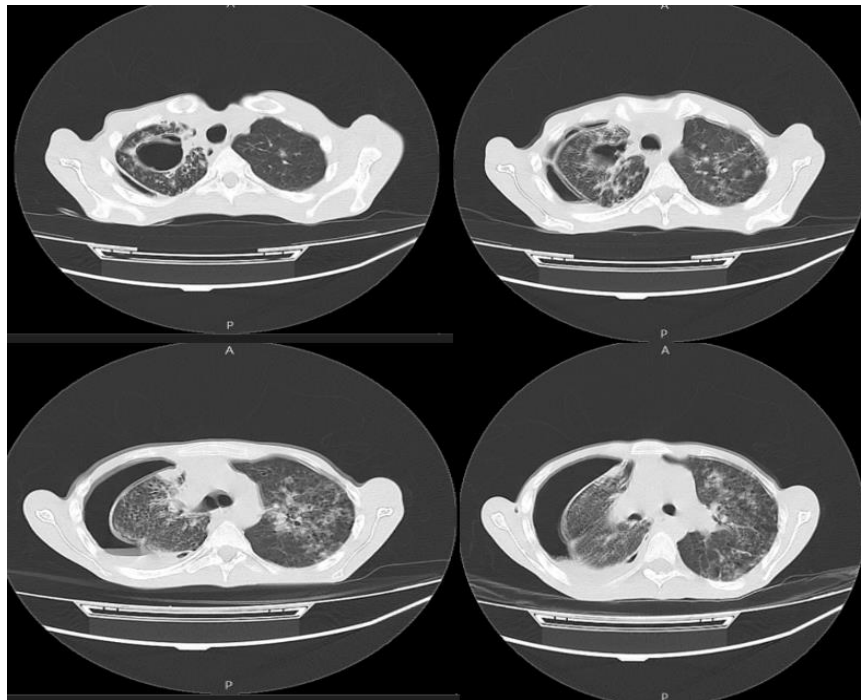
A spiral CT scan of the lung showing right-sided pneumothorax with a large air cyst with a maximum dimension of 54x30 mm on the right side and a maximum dimension of 19 mm on the left lung showing loculated pneumothorax and central acinar ground glass lesions with trachea mucus plug presenting bronchopneumonia
